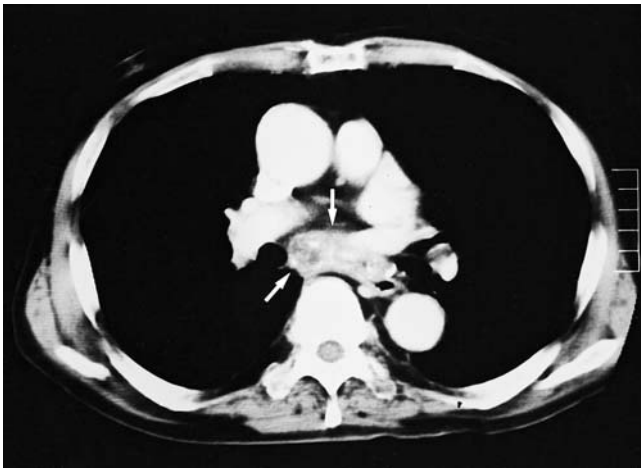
Chest computed tomography (CT) showed thickening of the middle thoracic esophagus and enlarged subcarinal lymph nodes, with thin peripheral enhancement and central low-density areas (arrows)
